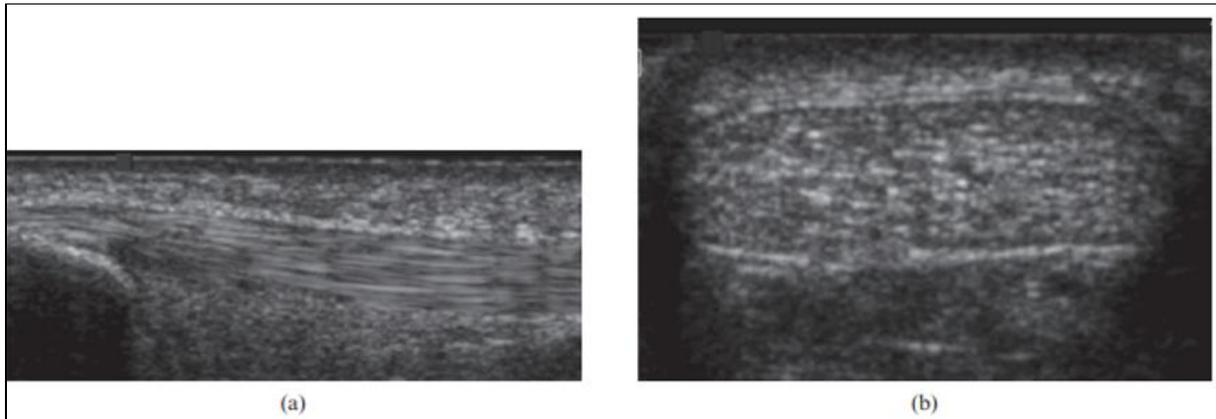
Ultrasound of normal Achilles tendon. Longitudinal (a) and transverse (b) ultrasound images of distal tendon. The normal tendon appears echogenic with multiple, parallel echogenic lines reflecting the internal fibrillar structure.²⁴
